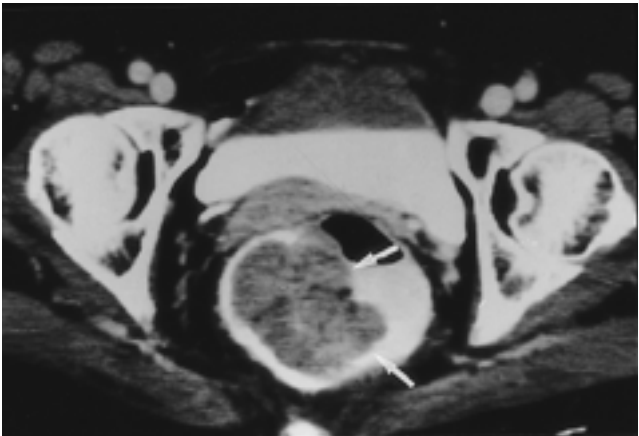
A 67-year-old woman with mucinous carcinoma. Contrast-enhanced CT shows intraluminal eccentric and polypoid mass (arrows) with heterogeneous hypoattenuation in the rectum.
